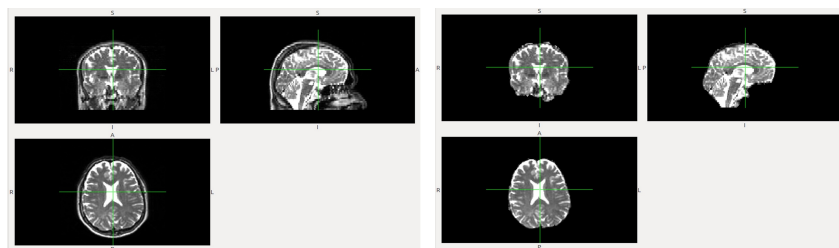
Brain MRI before (left) and after (right) eddy current correction.
